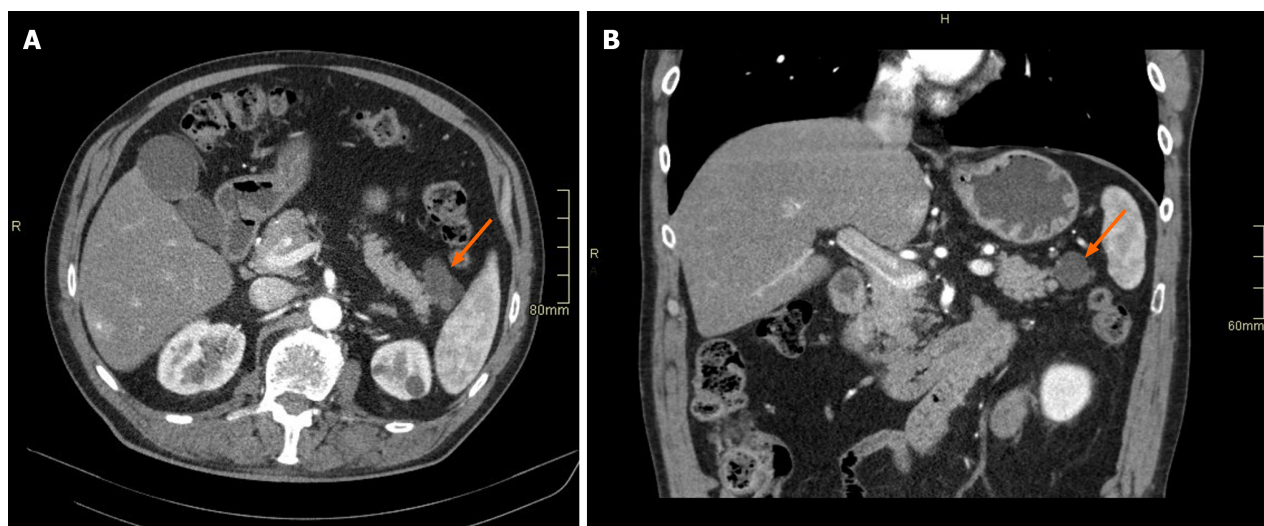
A lobulated lesion visualized by abdominal computed tomography scan in August 2019 (orange arrows). A: Axial view; B: Coronal view.
